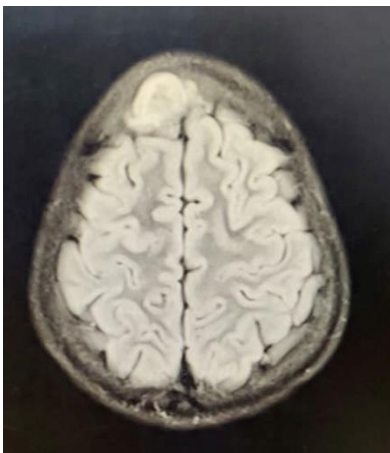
MRI scan showing well defined extra axial iso intense lesion broad base towards dura noted in frontal convexity showing peripheral enhancement.
